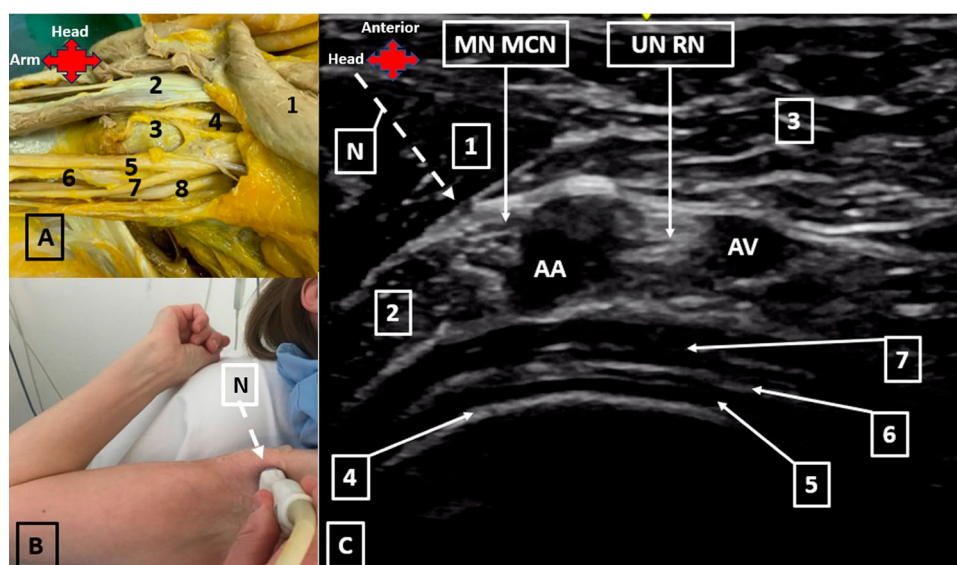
Figure (A) Complete dissection of the shoulder: 1) pectoralis major muscle, 2) coracobrachialis muscle, 3) the head of the humerus, 4) musculocutaneous nerve, 5) median nerve, 6) axillary artery, 7) ulnar nerve, and 8) radial nerve. (B) Position of the ultrasound probe on the head of the humerus and part of the pectoralis major muscle. (C) Ultrasound image of the brachial plexus at the level of the humeral head: 1) pectoralis major muscle, 2) coracobrachialis muscle, 3) fat, 4) cortical bone, 5) cartilage, 6) surface of the cartilage, and 7) the subscapularis muscle.
